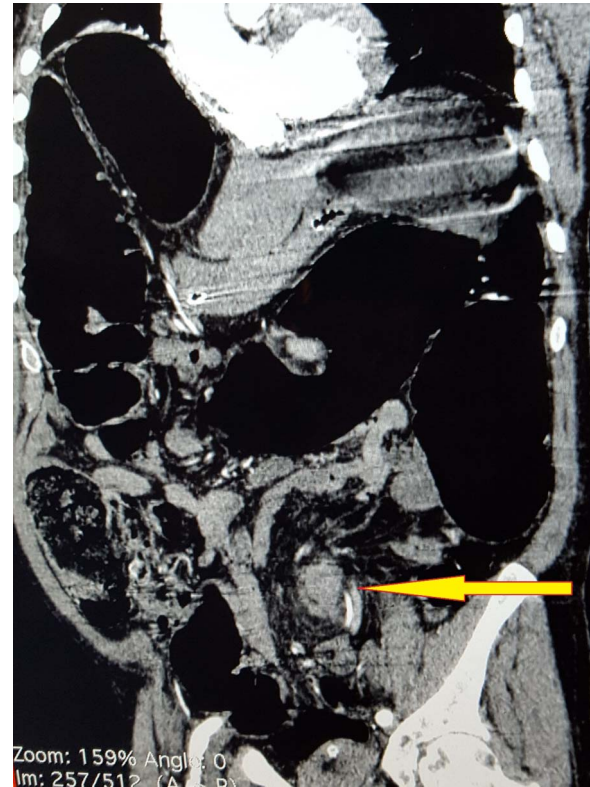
CT scan abdomen demonstrating whirl sign indicative of sigmoid volvulus.
